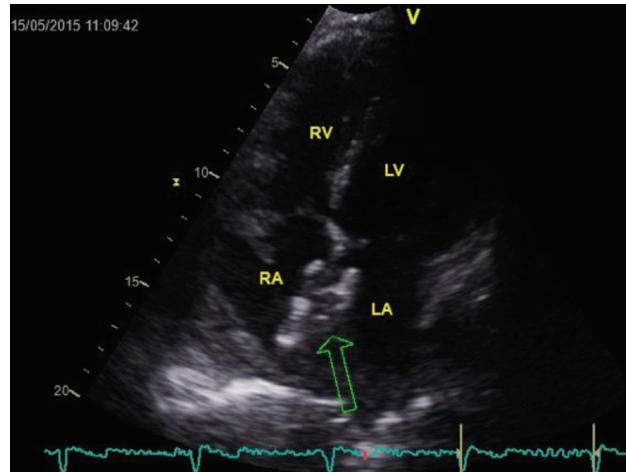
Transthoracic short axis view at the aortic level of atrial septal defect Amplatzer occluder (arrow) at the end of the procedure.
